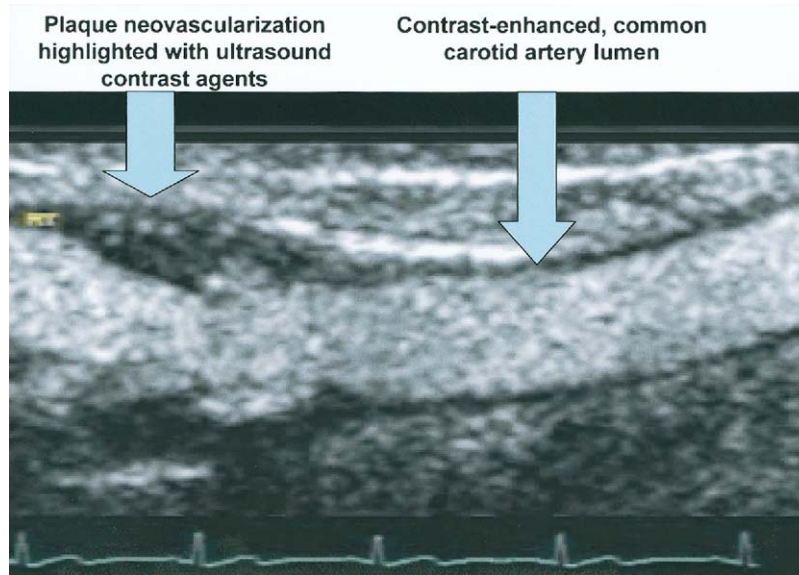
Ultrasound contrast agents enhance the vessel lumen and reveal the presence of intraplaque angiogenesis, emanating from the adventitial vasa vasorum.
